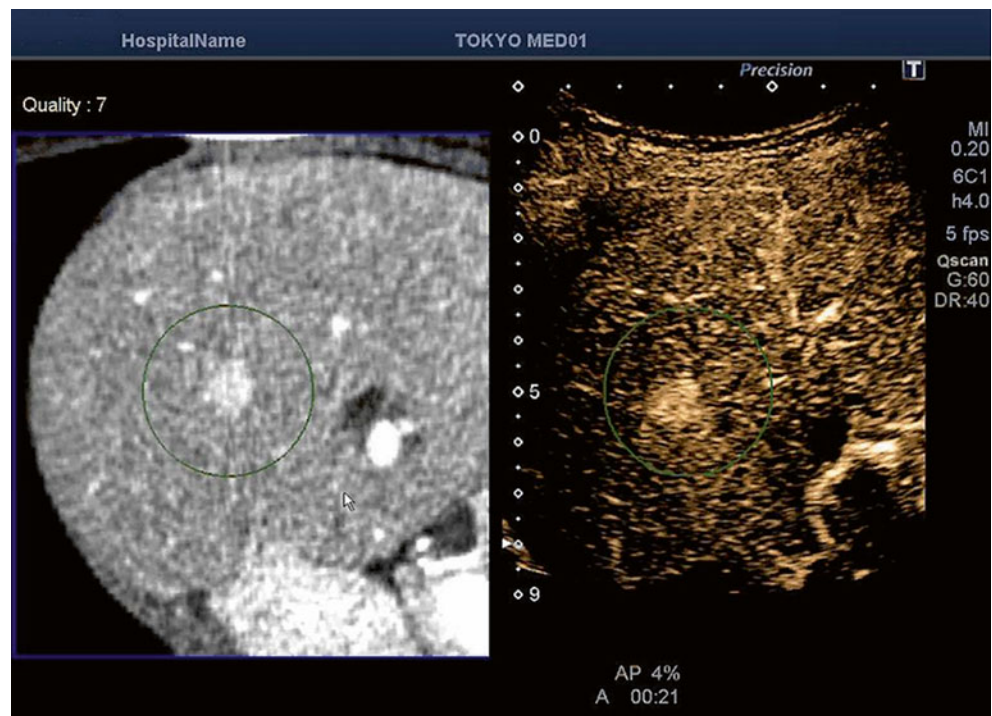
Fusion. CTA vs. CEUS (Sonazoid®). See also Video 23.10. CTA (*left*) and CEUS (*right*) showing enhancement of a tumor (*circle area*) by CEUS
